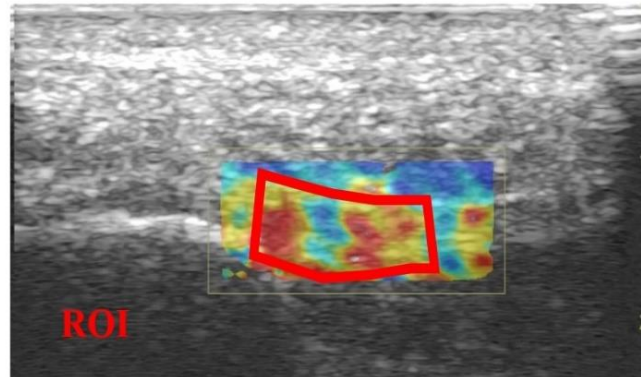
Representation of a shear wave elastography ultrasound image to measure PF stiffness at the proximal site.
